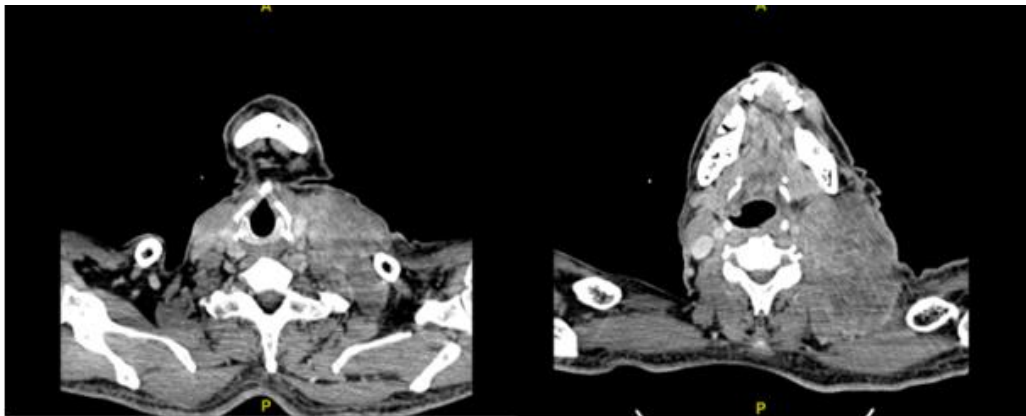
CT neck showing large left supraclavicular mass
